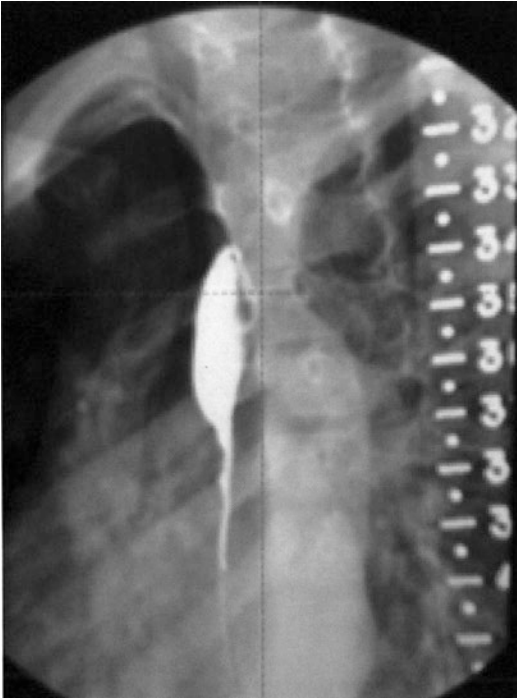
Radiograph of a 6-year-old male with a long congenital (fibromuscular hypertrophy) stricture. He had never eaten solid foods and even the swallowing of liquids was a laborious process. Although three resections were used to completely remove the 6.5 cm stricture, two might have been sufficient. The first two resections were done only 3 days apart, and there had been insufficient time to maximize the growth response; therefore, the second resection was smaller
